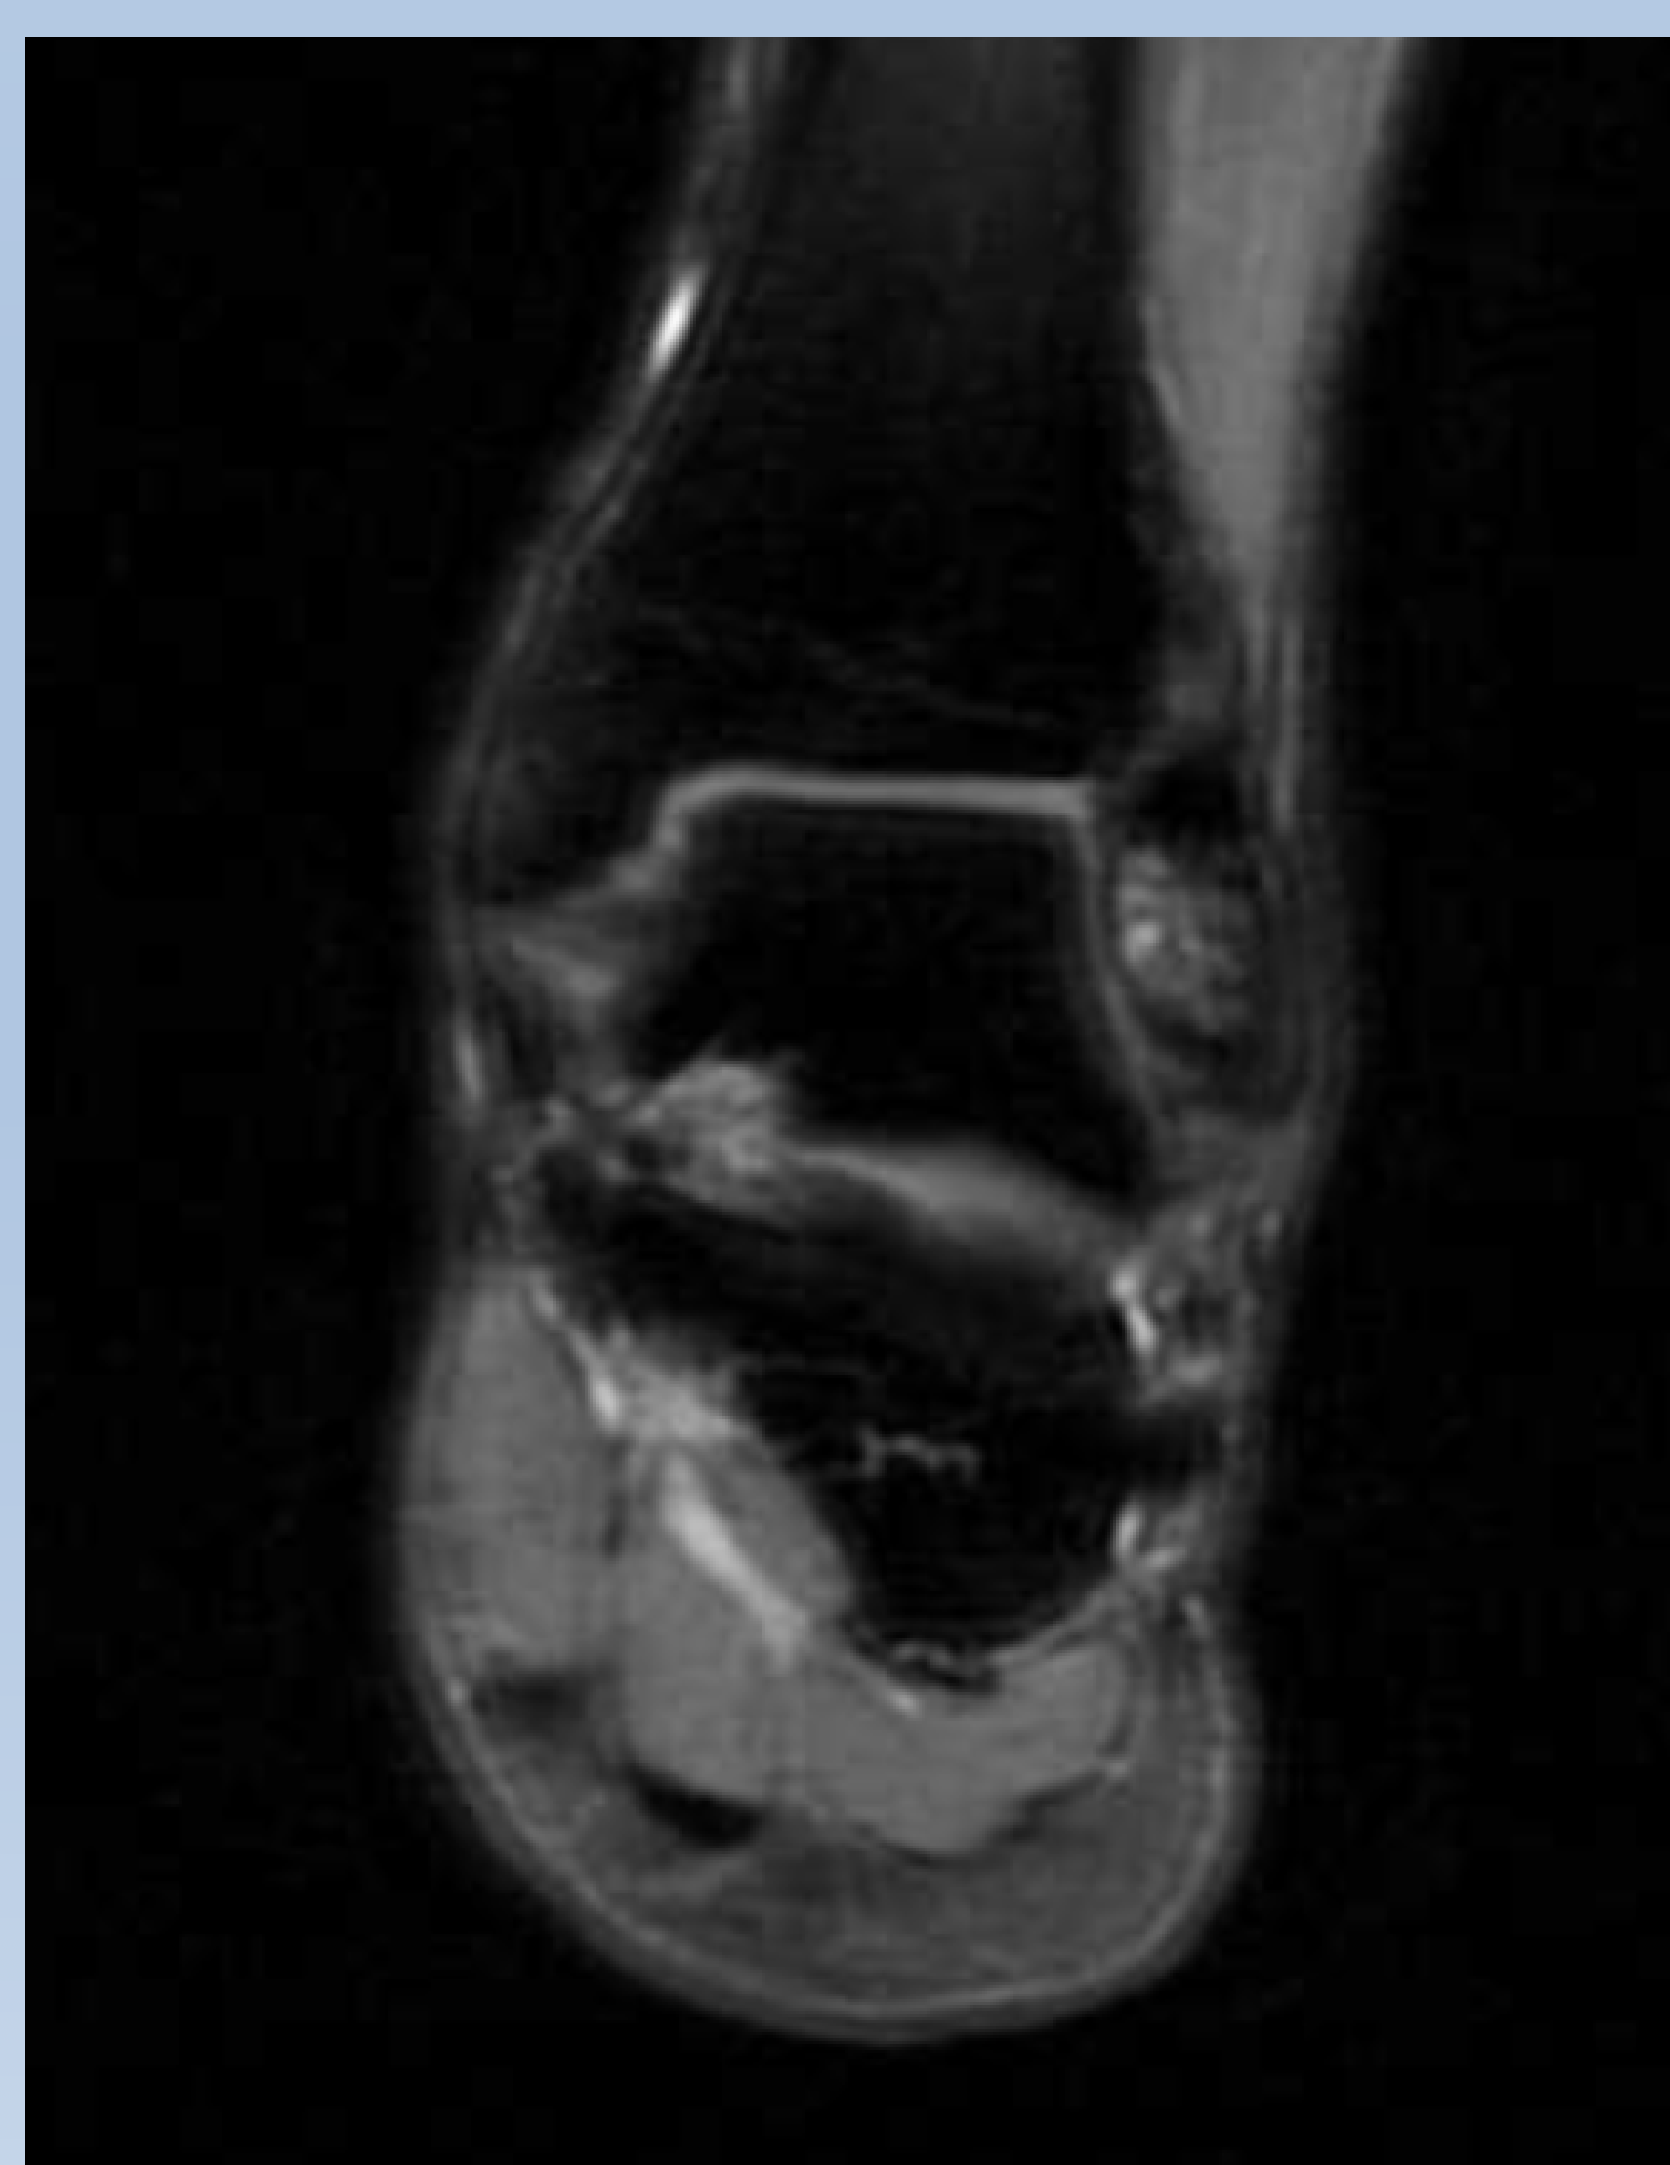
Coronal T2 MRI Left Ankle
